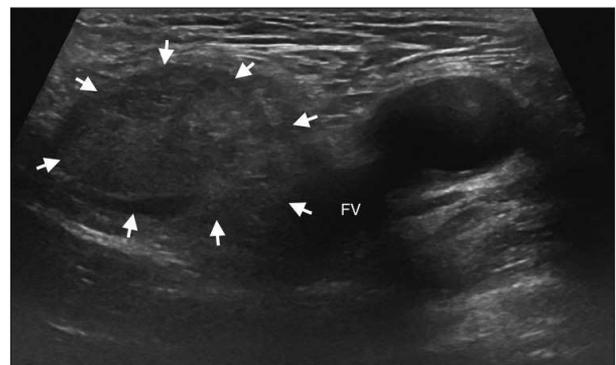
Left femoral hernia. Transverse sonogram showing herniation of peritoneal fat and a sac containing a trace amount of fluid (arrows) into the femoral canal medial to the femoral vein (FV). Partial effacement of the femoral vein by the hernia sac is shown.
